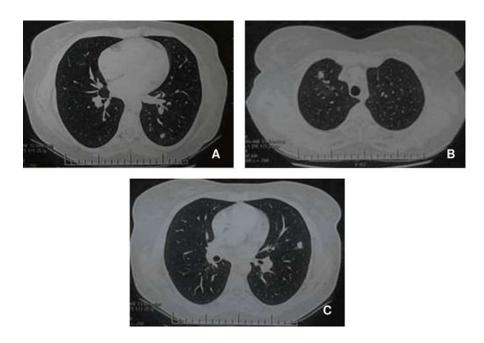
a lung high resolution computed tomography (HRCT) (A, B, C): showing bilateral and diffuse pulmonary intra-parenchymal nodules
